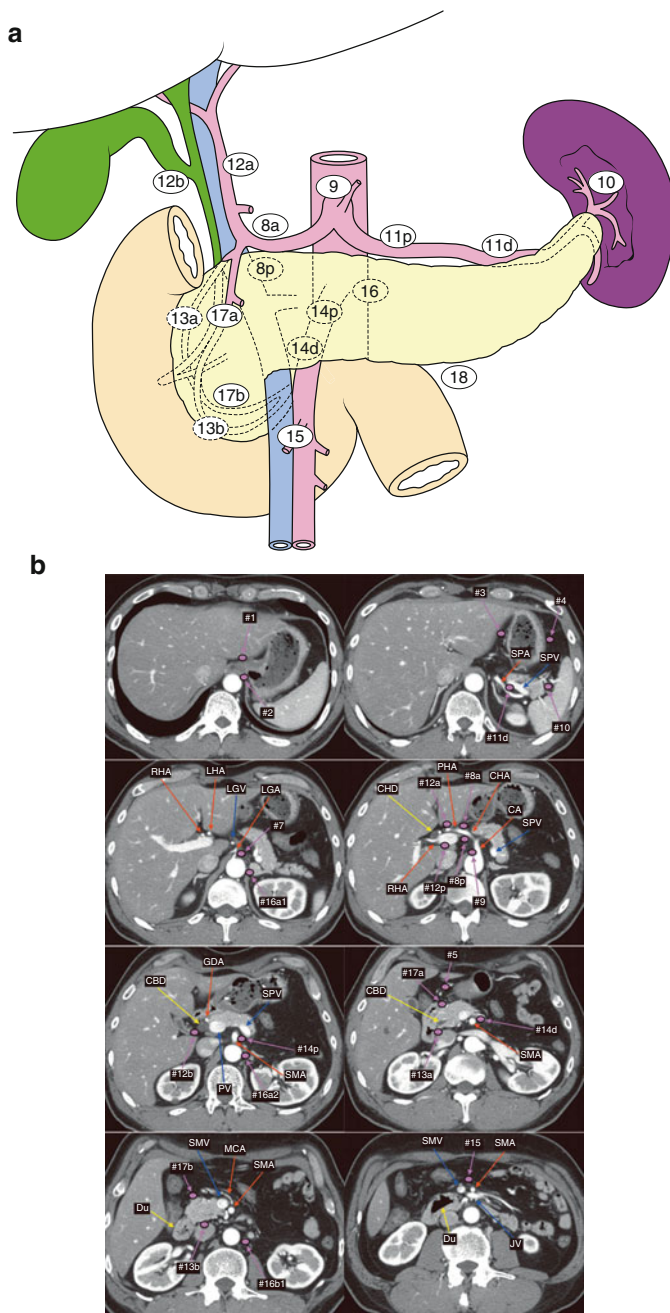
Lymph node station numbers related to the pancreas in Japanese classification of pancreatic cancer, seventh edition (Kanehara & Co., Ltd., Tokyo, Japan). (a) Scheme of lymph node station numbers related to the pancreas. (b) MD-CT finding (cross section) showing peripancreatic lymph
